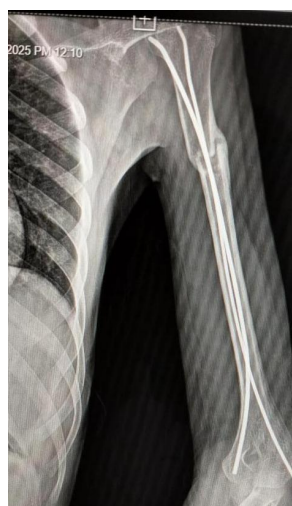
Follow-up AP view Xray after 3 months
